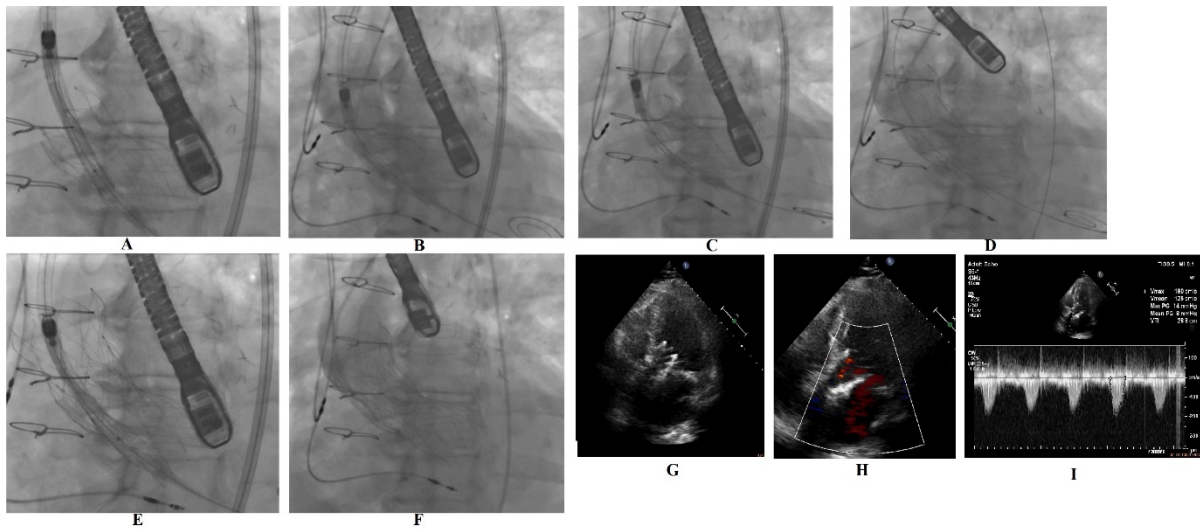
A second TAVI valve positioned over the Safari wire helped by the pigtail on the aortic root in the first valve as valve-in-valve (A-B-C); still moderate paravalvular aortic regurgitation (PAR) due to dislocation of the second valve seen on aortography after release of the second TAVI valve (D); the third TAVI valve is positioned over the Safari wire helped by the pigtail on the aortic root in the first two-valve as valve-in-valve-in-valve (E) and implanted successfully and there is minimal PAR on aortography after the third valve implantation (F); the valves draw attention due to the heavy metallic echogenicity on echocardiography (G); no paravalvular aortic regurgitation on transthoracic echocardiography before hospital discharge (H); and transaortic 14/8 mmHg gradient detected on TAVI valve
